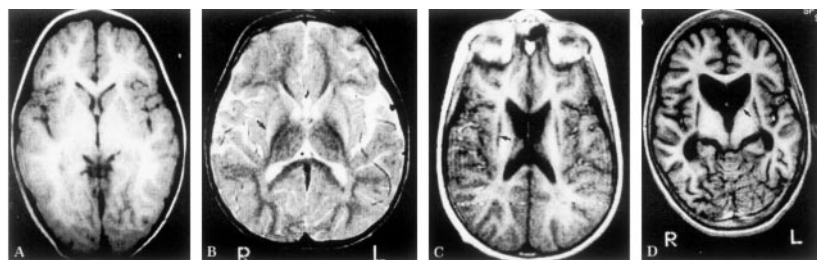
(A) Axial T1-weighted images of Patient VI-12 at 15 months. No abnormalities are seen. (B) Axial T2-weighted images of Patient VI-10 at 21 months. Note localized high signals only in the posterior putamen. There is no volume loss in the striatum (arrow). (C) Axial T1-weighted images of Patient VI-7 at 6 years. The caudate and putamina have diminished in size. Note the low signals from the putamina (arrow). (D) Axial T1-weighted images of Patient VI-12 at age 11 years. Only minimal residual caudate (arrow) and putamina are visualized. Note the diffuse parenchymal loss. (Reprinted with permission from Straussberg et al).¹¹
